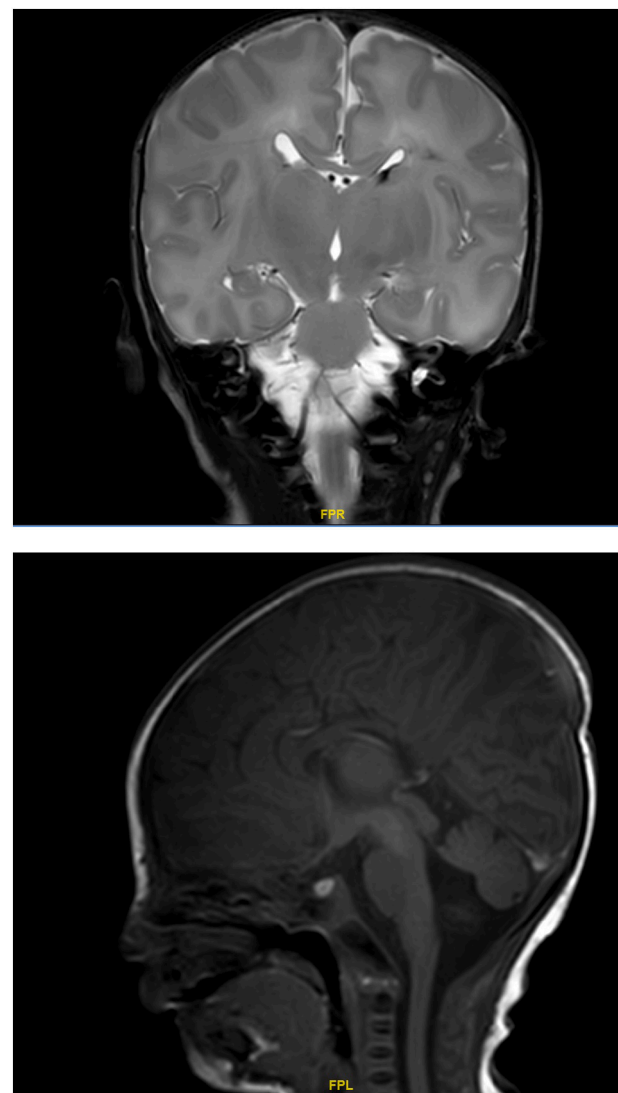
Magnetic resonance image showing A. Rotated vermis. B. Hypoplastic corpus callosum.
